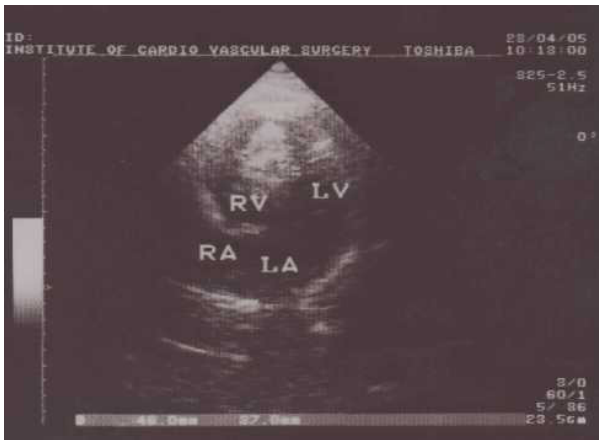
Transthoracic ECHO of patient B. Tumor in the RV apex
